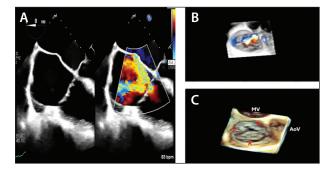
A 0° midesophageal TEE view with and without color Doppler and severe TR where the jets splay out into the right atrium (A). Three-dimensional views of the tricuspid valve with and without color Doppler where there is a coaptation defect centrally (B, C). A, anterior leaflet; AoV, aortic valve; MV, mitral valve; P, posterior leaflet; S, septal leaflet.
